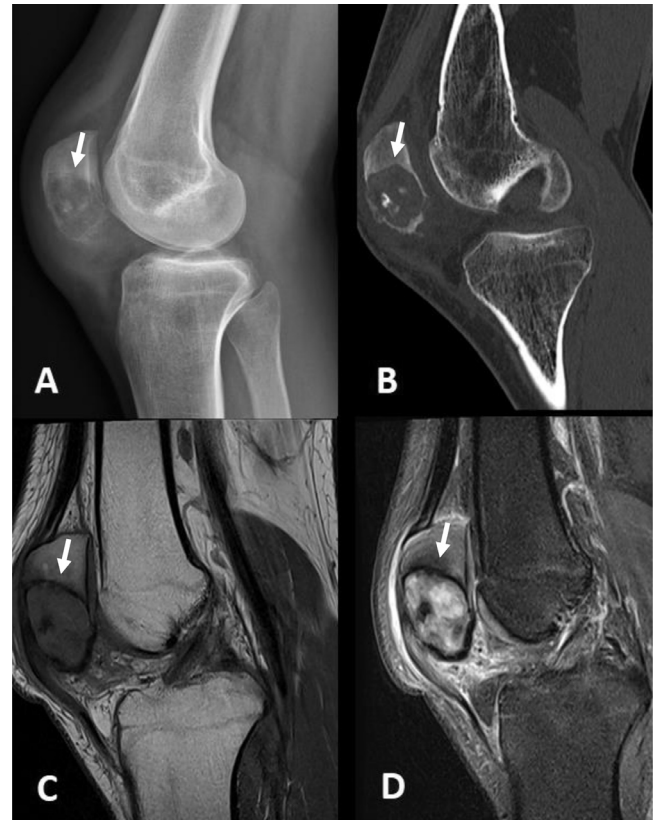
(A) Preoperative lateral x-ray of patella demonstrating an osteolytic lesion of distal two-third of the patella (white arrow). (B) Preoperative CT scan showing osteolytic lesion with calcification (white arrow). (C) Preoperative MRI T1 weighted image showing a hypointense lesion (white arrow). (D) Preoperative MRI T2 weighted image showing a hyperintense lesion (white arrow).
